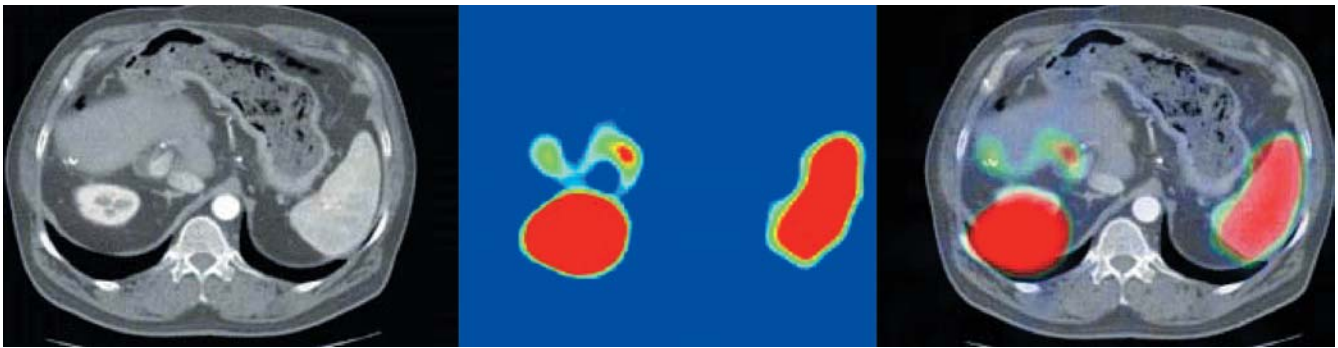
Original and fused images from a 62-year-old male patient after resection of the pancreatic primary, right-sided hemihepatectomy and enucleation of liver metastases. The CT scan is shown on the *left*, the corresponding SPET image in the *centre* and the fused image on the *right*. The current SRS-SPET showed a focus suspected to be a hepatic lesion. For further clarification of the localization, image fusion was performed. However, as physiological accumulation in the right kidney was partially projected into the thorax according to the corresponding CT scan, this registration was considered to be invalid for evaluation and the patient was excluded from the study. Alterations of the patient's breathing pattern and the resulting changes in diaphragmatic excursions or different positioning of the patient were considered as possible reasons for this unsuccessful image fusion
